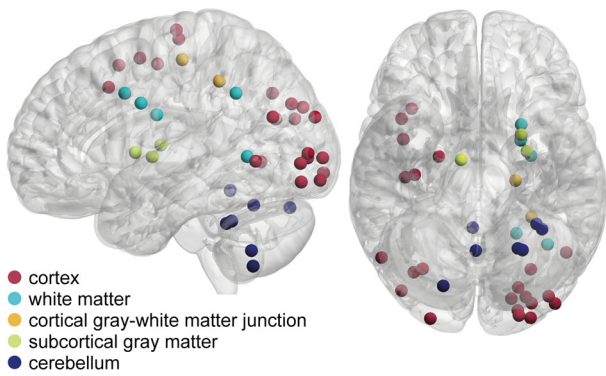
Distribution of diffusion-weighted imaging positive (DWI+) lesions. The distribution of DWI+ lesions is depicted in Montreal Neurological Institute–152 standard space. The image was created using BrainNet Viewer (<http://www.nitrc.org/projects/bnv/>).
